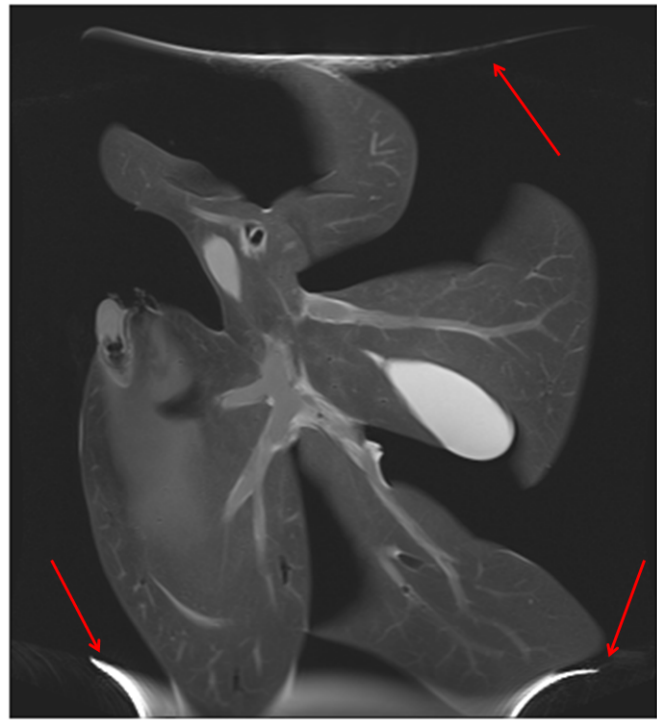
A single slice of the T2-weighted scan of the liver perfused with blood. The scan was performed using a 2D turbo spin echo sequence.
